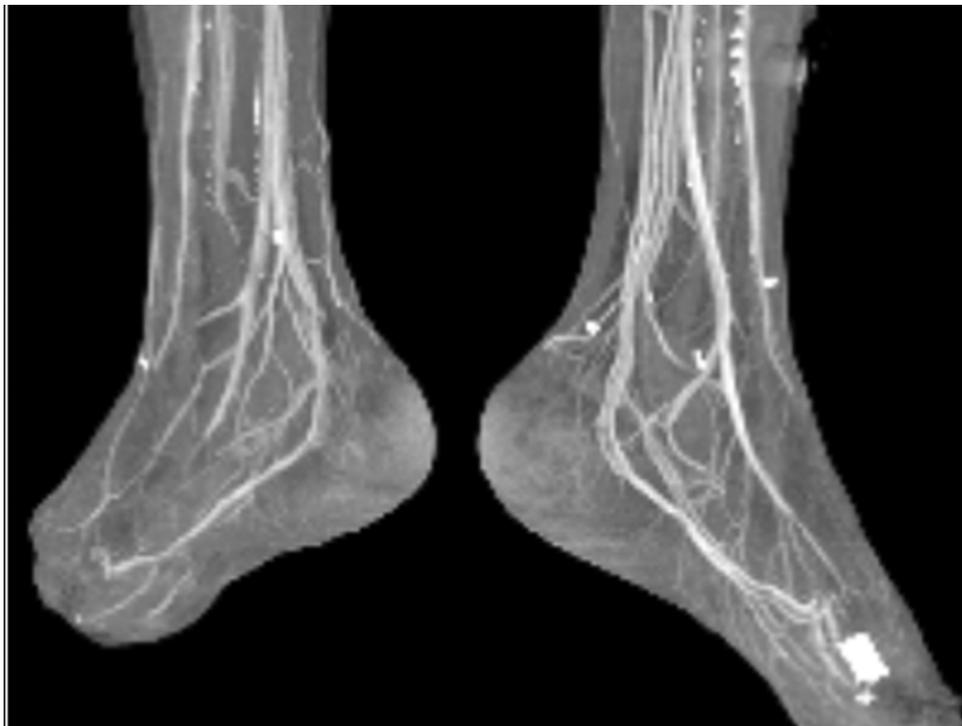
CT angiogram of bilateral feet noting patent proximal arterial perfusion to the hindfoot and midfoot as part of preoperative planning.
